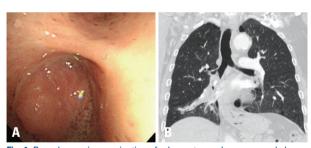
Bronchoscopic examination of a hamartoma shows a round shape, smooth and rough surface, pinkish color, and no visible vessels on the tumor surface. Spontaneous bleeding was absent (A). Chest computed tomography shows a 25-mm calcified ovoid nodule at the distal bronchus intermedius and atelectasis of the right middle lobe (B).
